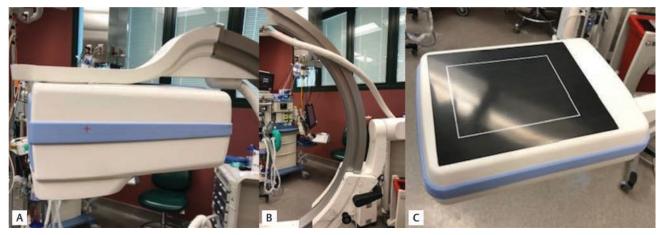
(A) X-ray tube (top) portion of the MCA. (B) Middle portion of the MCA. (C) Image intensifier (bottom) portion of the MCA. MCA, miniature c-arm.
